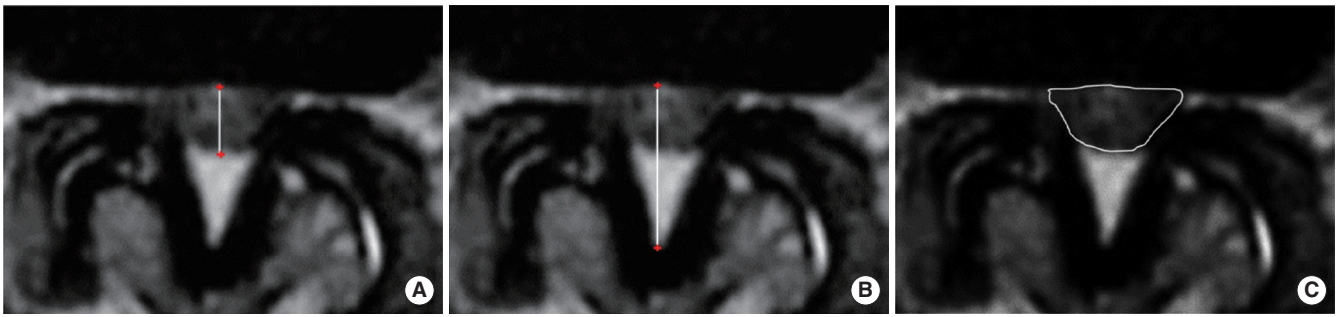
The preoperative T2-weighted axial magnetic resonance imaging with the most severe stenosis of each spinal level was utilized to measure the midline dural sac diameter (A), midline spinal canal diameter (B), dural sac cross-sectional area (C).
